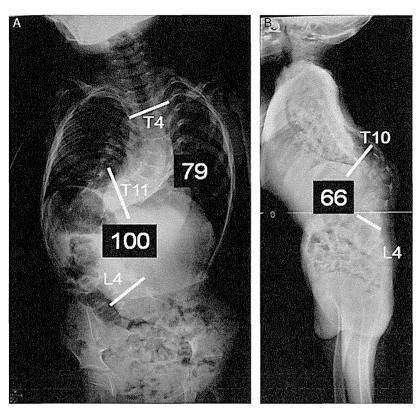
Preoperative radiographs of Patient 2. A double curve pattern with Cobb angles of 79 and 100 degrees (A) and local kyphosis of 66 degrees at the thoracolumbar junction are shown (B).
